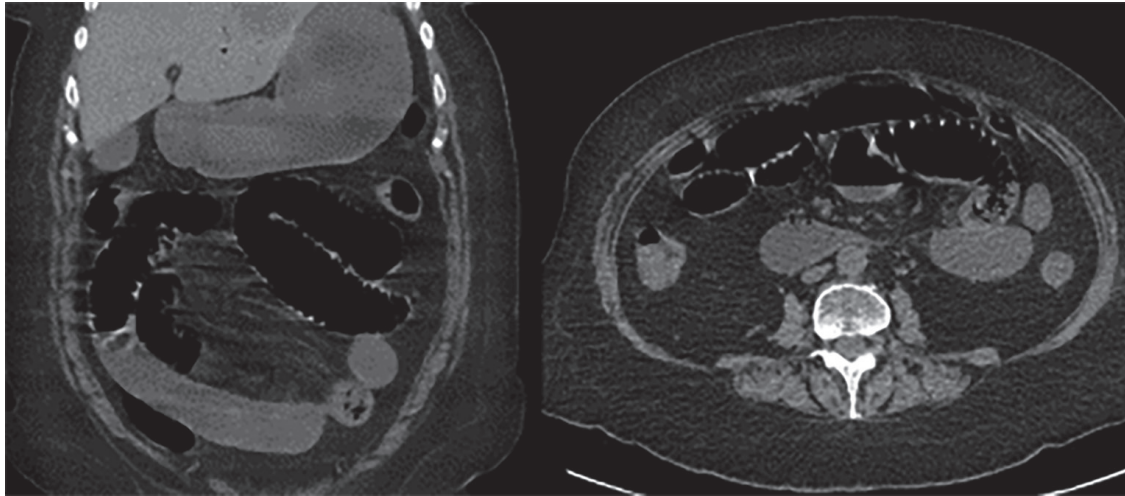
Preoperative CT-scan (axial and coronal image) showing dilated small bowel loops without obvious stenosis.
